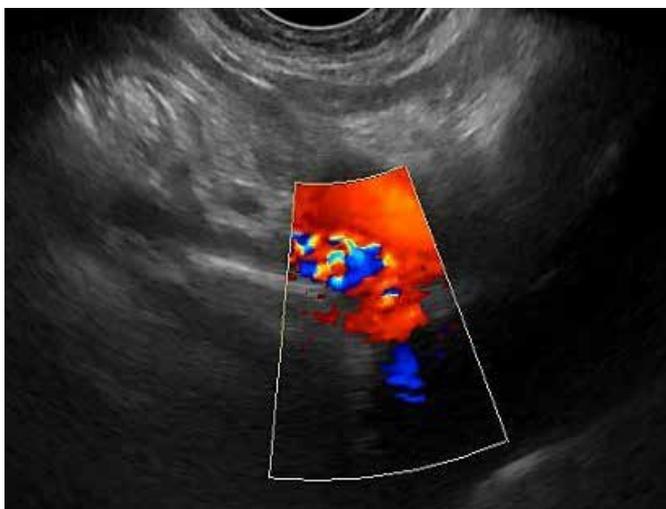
Color Doppler of the left subclavian artery showing the aliasing phenomenon. Image obtained by placing the endovaginal convex transducer in the patient's sternal furcula.
